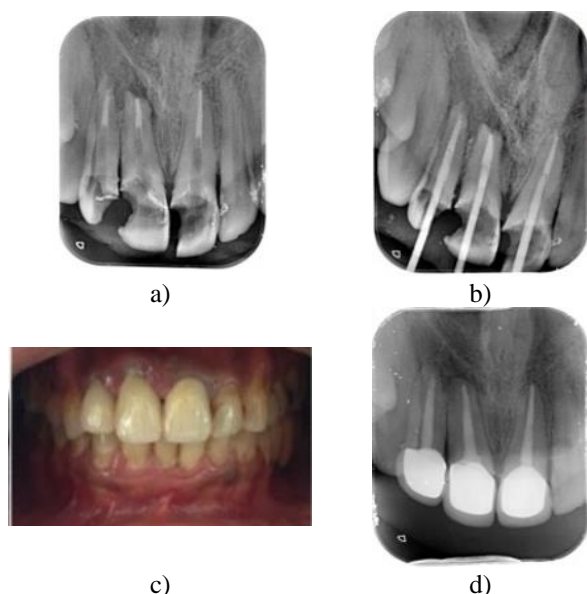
a) Radiograph showing a 5mm biodentine plug at the apical portion. b) Radiographic image showing the placement of fiber post. c) Postoperative Image. d) Radiographic image of 2 years follow up which shows the formation of the calcific barrier in the apical end
